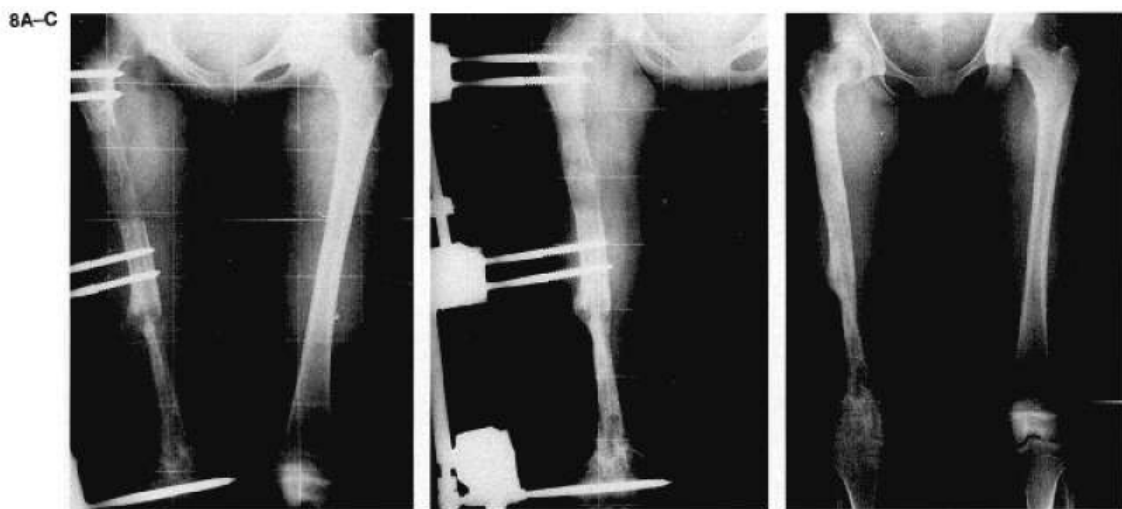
A and B: Radiographs taken during lengthening period show technique using an external fixation with three pin holders and a proximal metaphyseal osteotomy. C: Final result after lengthening.
